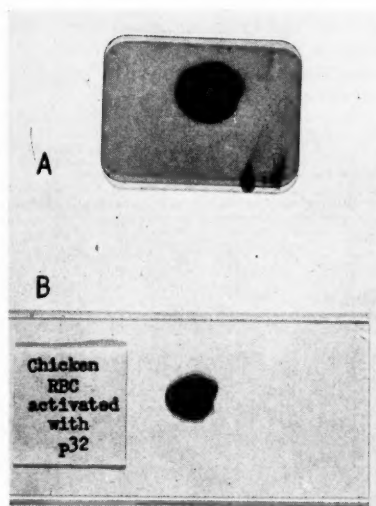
(A) Radioautograph, on x-ray film of (B) thick smear of P³² tagged chicken erythrocytes.
